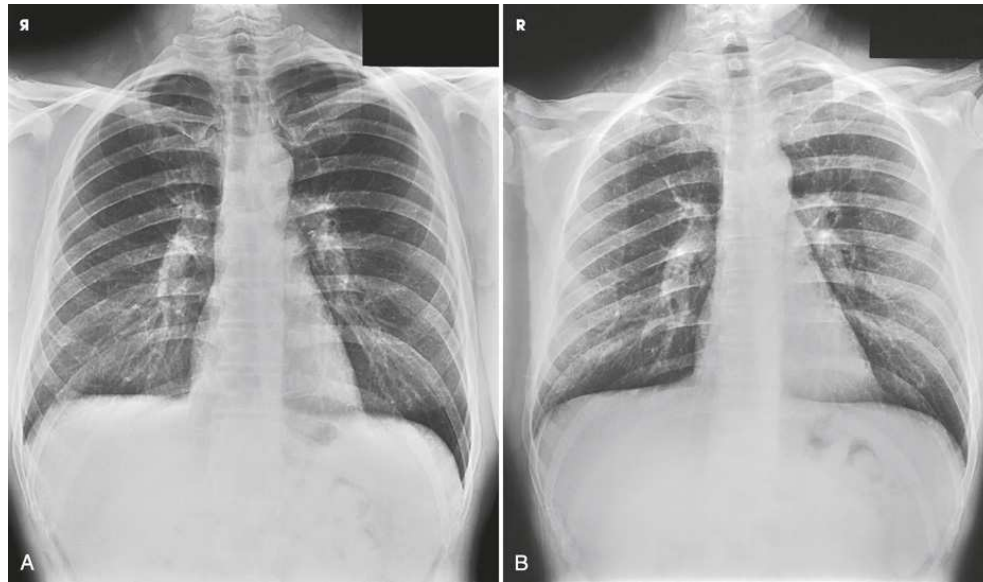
(A) PA projection of the chest. (B) AP projection of the chest. Both radiographs are correctly displayed with the anatomy in the anatomic position even though the patient was positioned differently. Note that the patient's left side is on your right, as though the patient were facing you.
